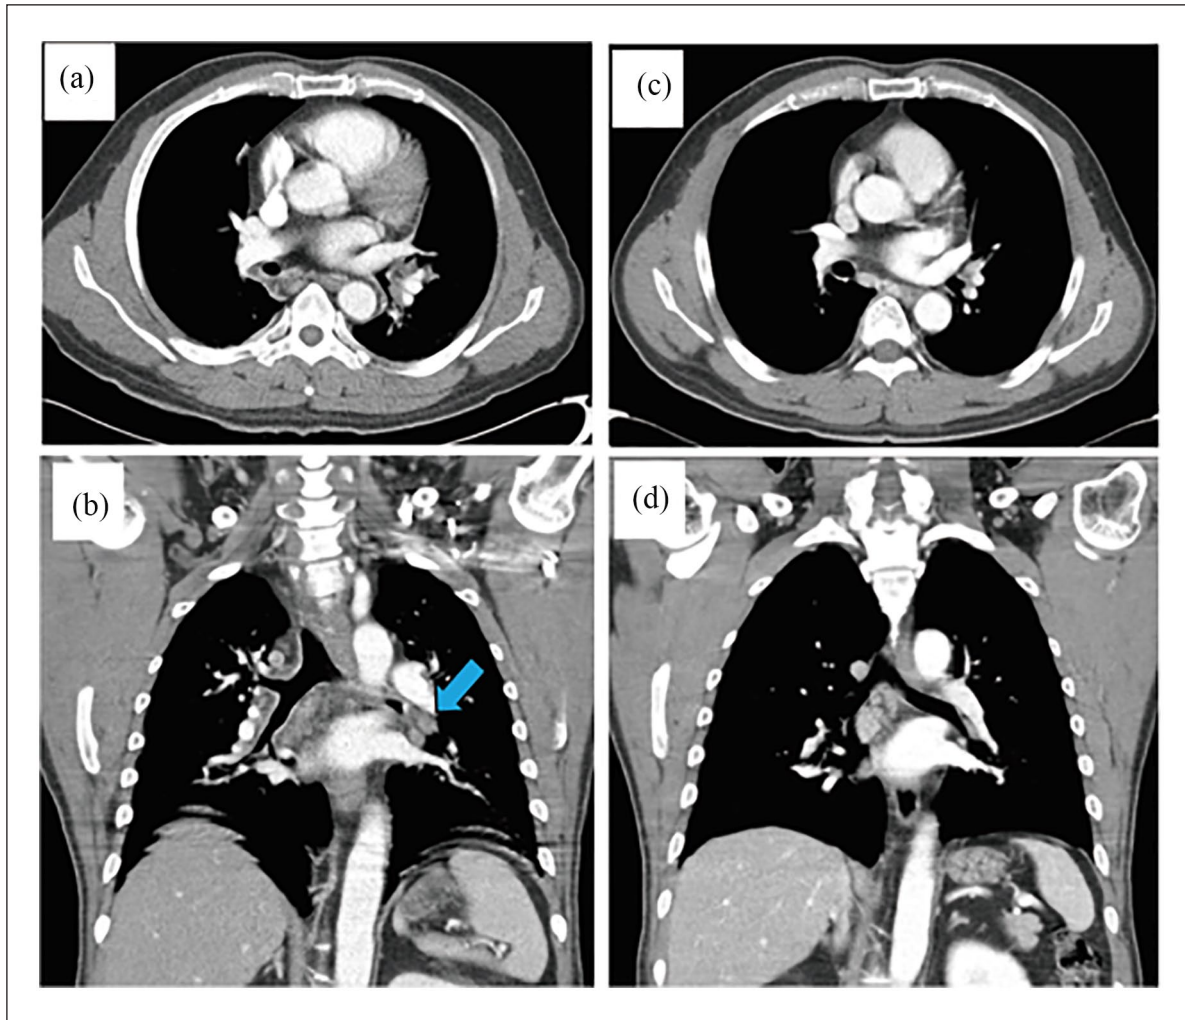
Initial and follow-up chest CT findings: (a) The initial transverse CT scan revealed diffuse bronchial wall thickening and luminal narrowing of the lobar and segmental bronchi. (b) The initial coronal CT scan revealed a 7.7 mm diameter mass-like lesion suggesting endobronchial tumor in a left lingular bronchus (arrow) and enlargement of multiple mediastinal LNs enlargement. (c) On the follow-up transverse CT scan, the bronchial wall thickening had significantly improved. (d) On the follow-up coronal CT scan, previous mass-like lesion and mediastinal LNs significantly decreased.
